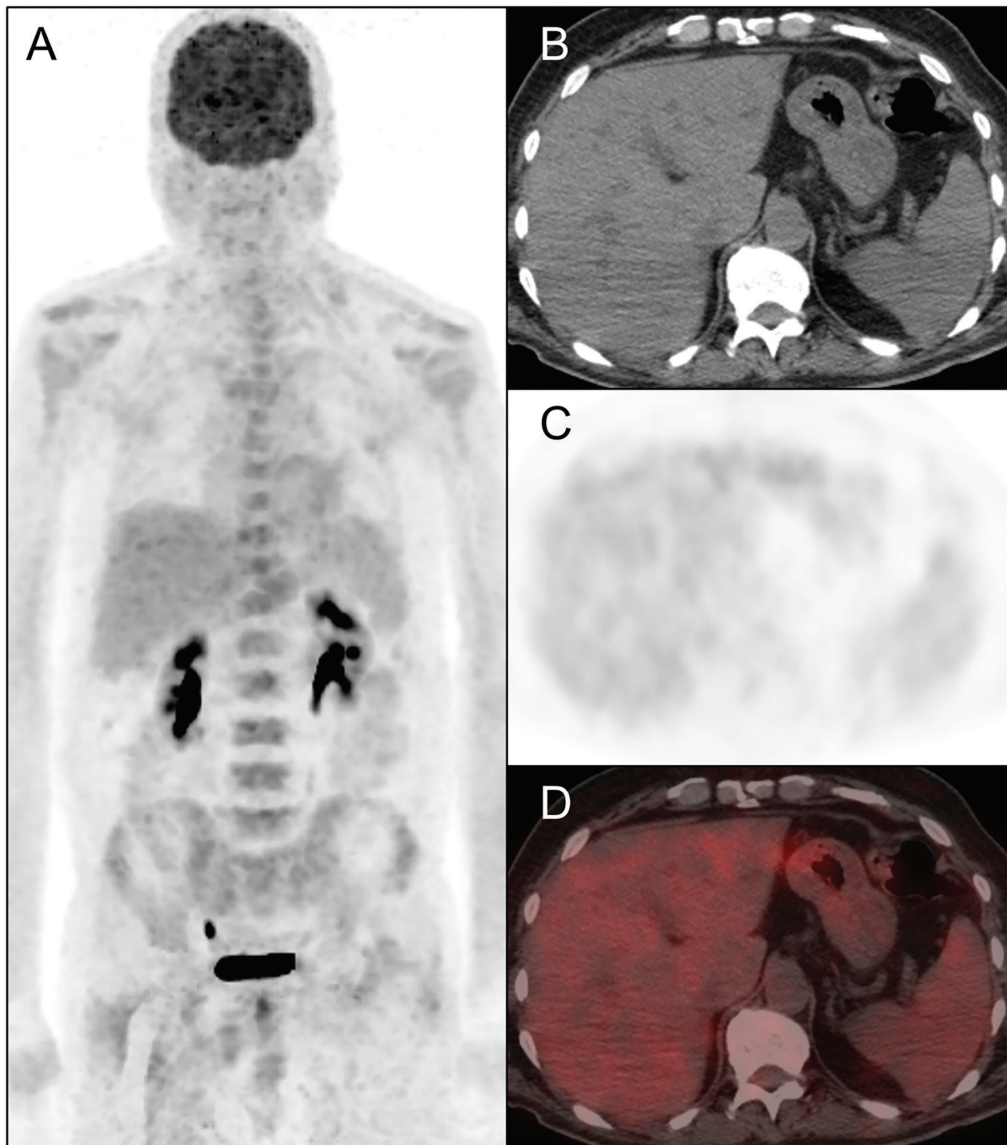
Follow-up ¹⁸F-fluorodeoxyglucose positron emission tomography/computed tomography (¹⁸F-FDG PET/CT) findings after systemic therapy 3A. MIP image demonstrates interval decrease in diffuse skeletal ¹⁸F-FDG uptake compared with baseline, with no newly emerged focal hypermetabolic lesions. Hepatic¹⁸F-FDG activity remains homogeneous and within physiological limits 3B. Axial low-dose CT image shows regression of hepatomegaly with improved hepatic contour and parenchymal homogeneity, with the craniocaudal liver length measuring approximately 15.6 cm 3C. Axial PET image at the hepatic level demonstrates persistently low-grade, diffuse ¹⁸F-FDG uptake within the liver parenchyma, without abnormal focal activity. 3D. Axial fused ¹⁸F-FDG PET/CT image confirms the absence of focal hepatic ¹⁸F-FDG uptake and demonstrates interval improvement of hepatic findings following systemic therapy, in keeping with the observed clinical improvement.
